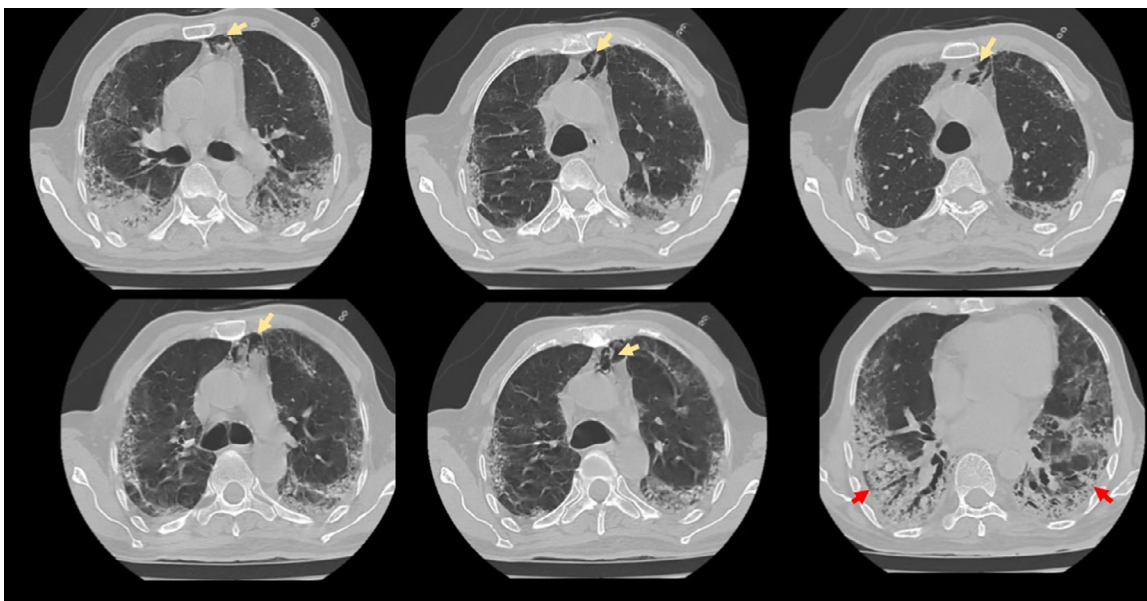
Chest CT scan of Patient Two showing SPM (yellow arrows), bilateral peripheral ground-glass opacities, and consolidations (red arrows). (Color version of figure is available online.)
